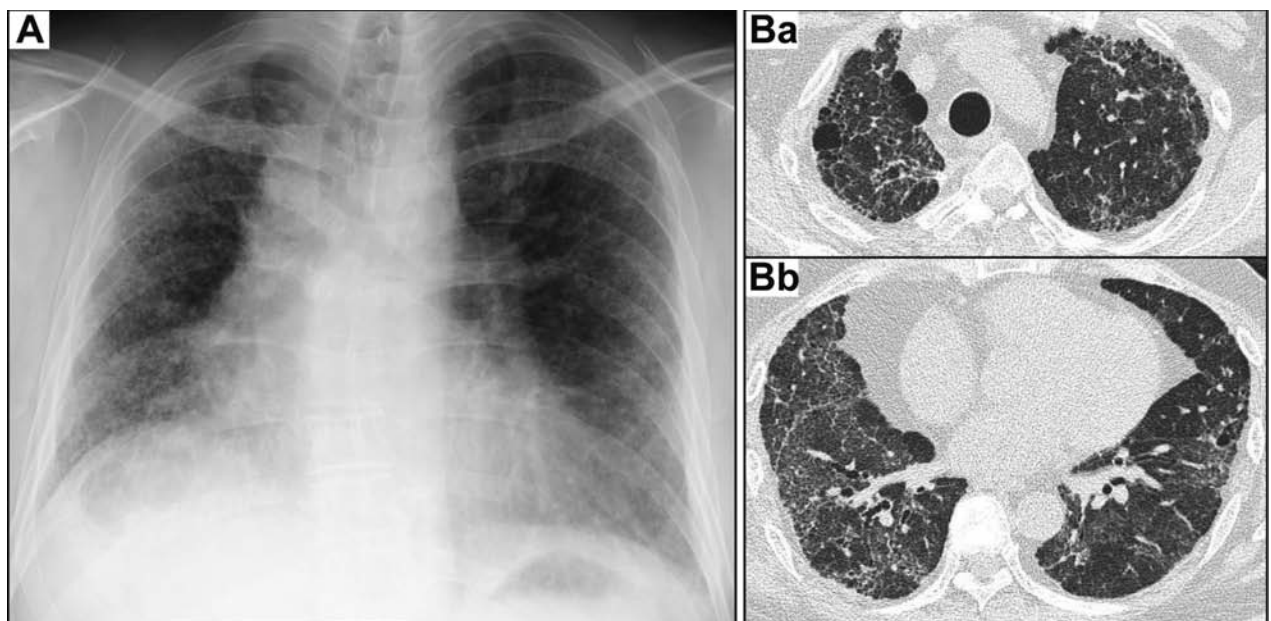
(A) The chest X-ray, showing significant loss of lung volume. (B) High-resolution computed tomography of the chest, showing diffuse reticular and ground-glass changes in the upper (Ba) and lower (Bb) lung fields. Although basal subpleural honeycombing was not apparent, subpleural cysts in the upper lung fields were noted.
